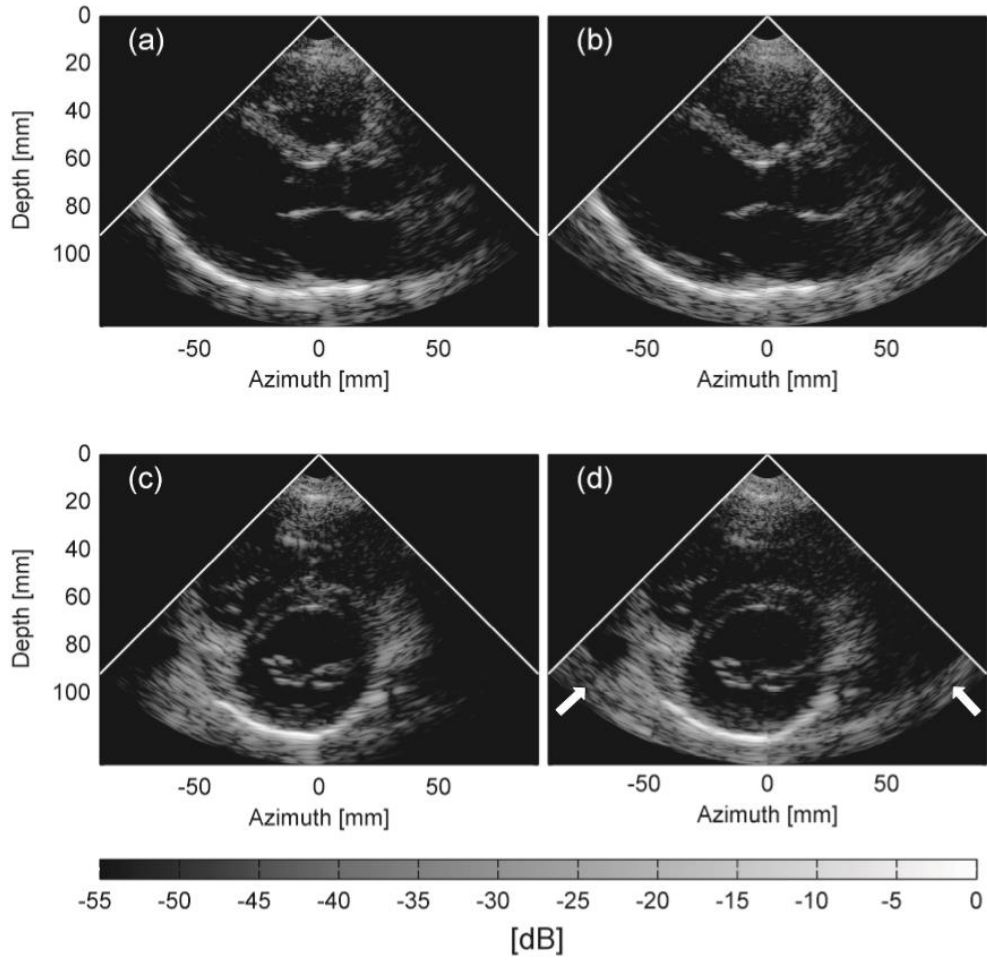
Sample images acquired from the parasternal long axis view (upper panels) and short axis view (lower panels) using SLT/4MLT imaging setup with Tukey ( $\alpha = 0.5$ ) apodization on transmit and receive. The images on the left were acquired using the SLT interleaved with the 4MLT. Reproduced from [21] with permission.
